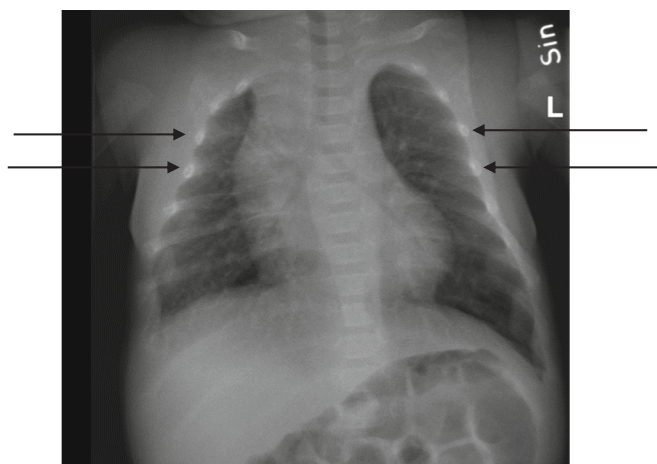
X-ray with arrows indicating generalized skeletal demineralization.
